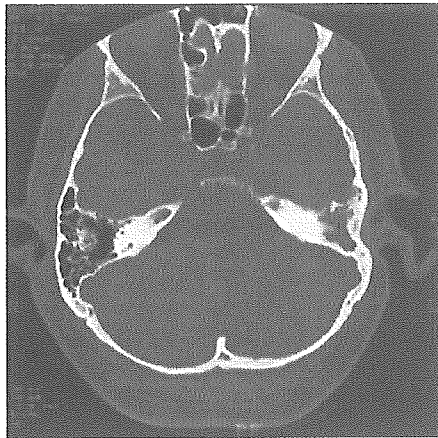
Computed tomography scan image of the patient with the chronic otitis media. The development of mastoid air cells in the left side is very poor. Thick, compact bone occupies the mastoid cavity instead of mastoid air cells. This is a typical image of the cases of chronic otitis media (cholesteatoma).
